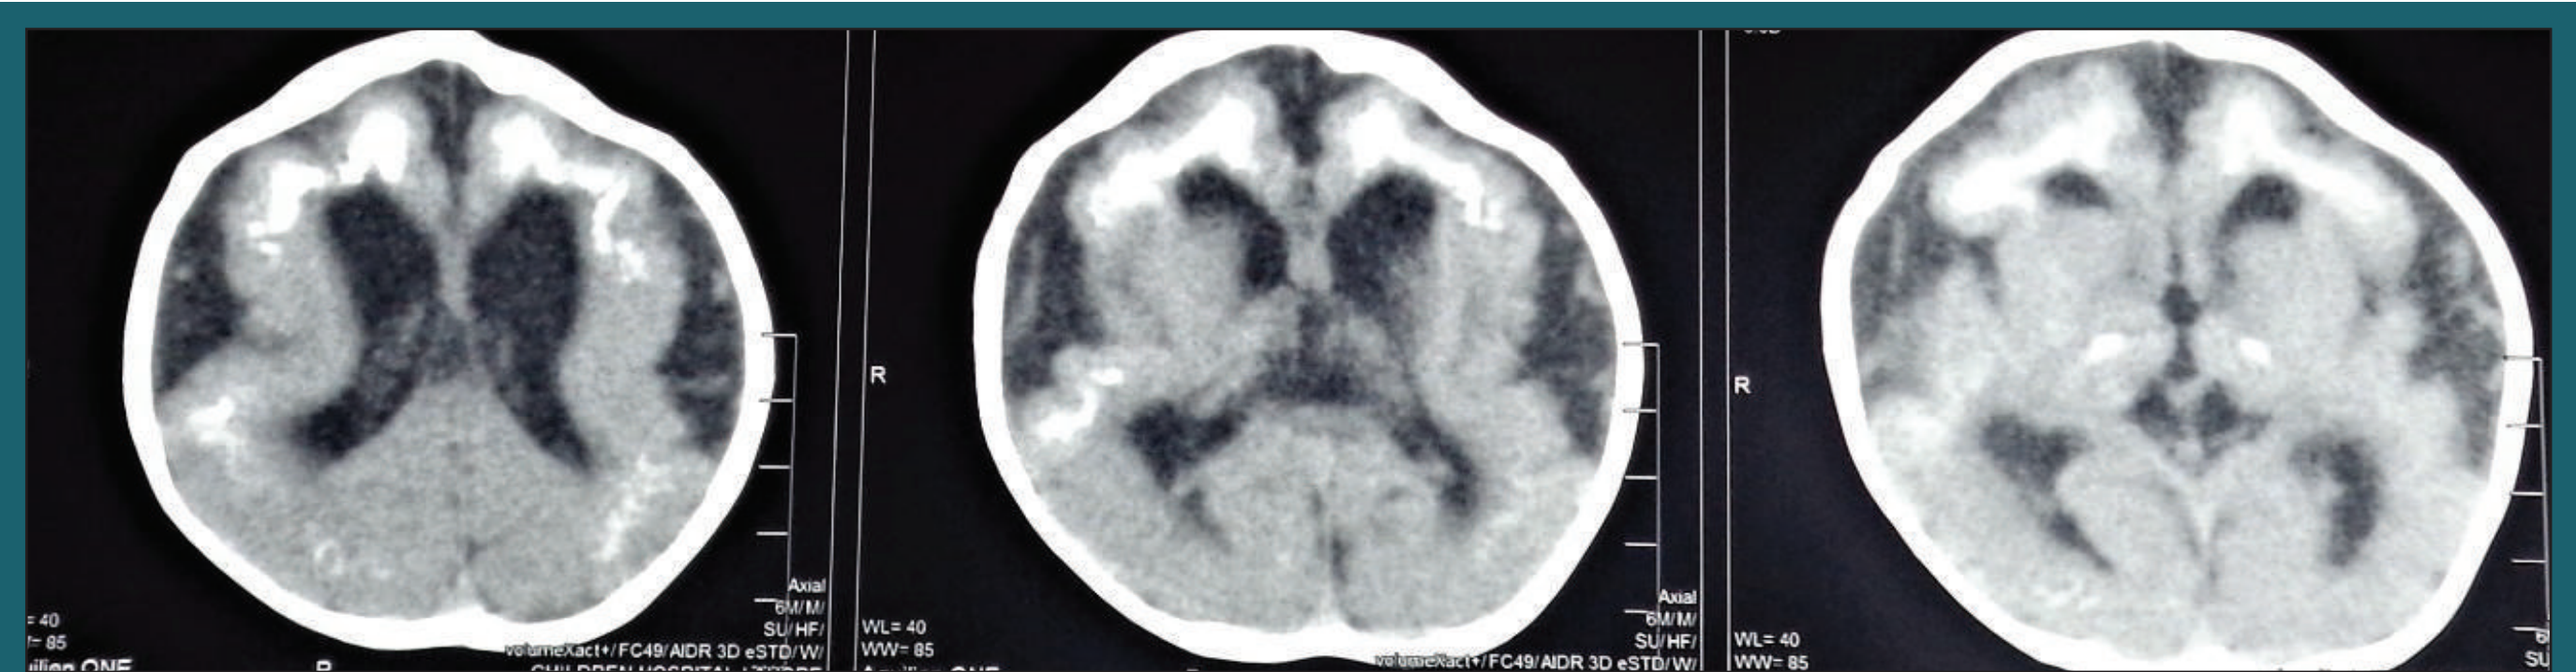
CT Brain showing extensive parenchymal, thalamic calcification with atrophic changes
